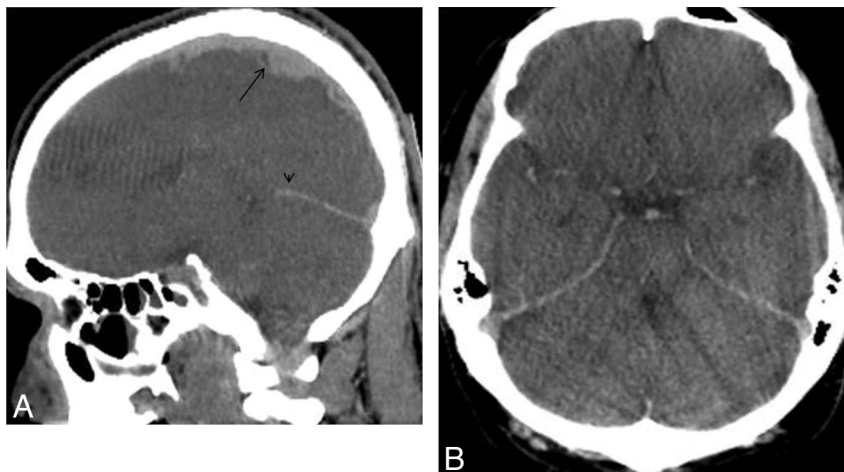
Increased vascular attenuation. *A*, Sagittal reformation from a noncontrast CT reveals high attenuation within the sagittal (arrow) and straight sinuses (arrowhead). The irregular appearance of the sagittal sinus is related to the cortical veins draining into the sinus. *B*, Axial noncontrast CT through the level of the circle of Willis reveals increased attenuation within the arteries. The beam-hardening artifact is related to the grommets on the human remains pouch.
